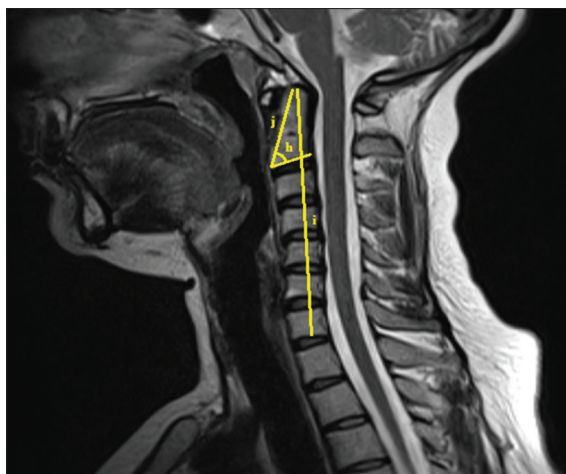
Sagittal Image Of The Head And Neck Region Obtained By Magnetic Resonance Imaging, h: Dens Axis Angle, i: Total Length Of Cervical Vertebrae, j: Anterosuperior Distance Of The Dens Axis
